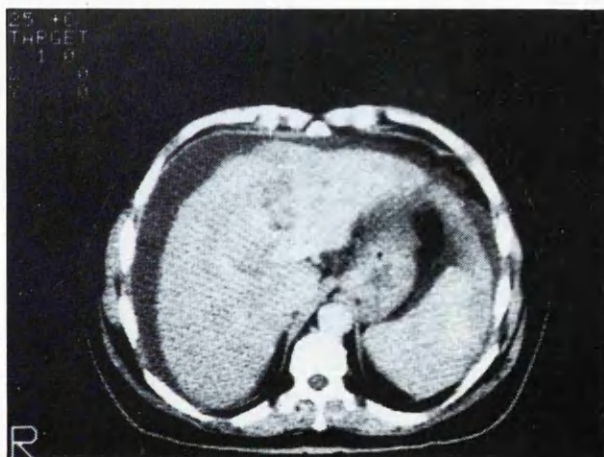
CT scan shows mass lesion in the liver.
